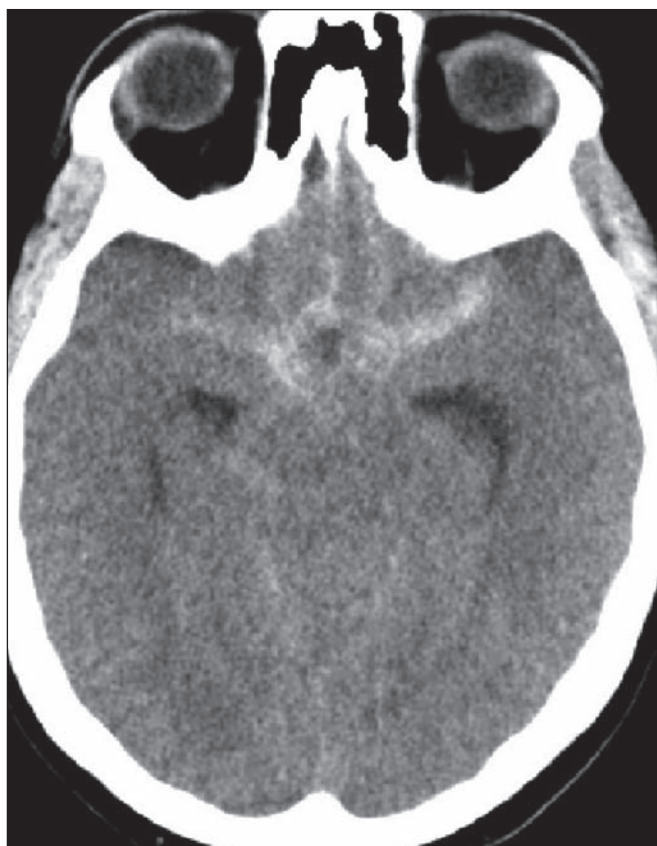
Subarachnoid hemorrhage in the basal cisterns in a non-contrast CT scan of the brain.
